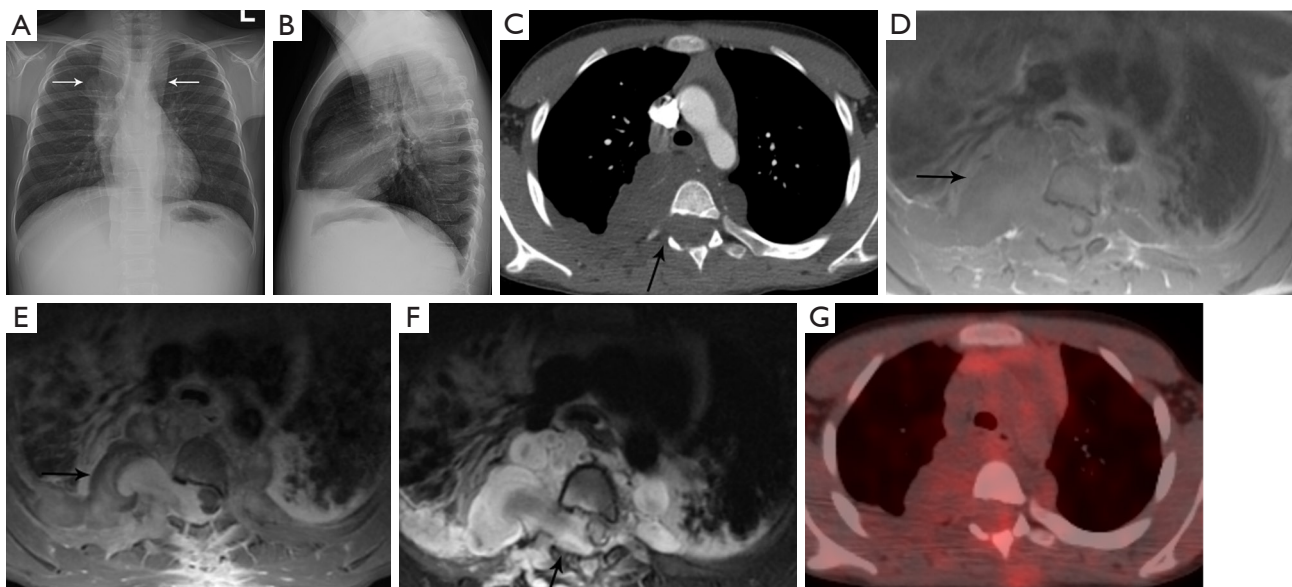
Ganglioneuroma. (A,B) PA and lateral chest radiographs show elongated bilateral posterior mediastinal lesion (arrows) extending from the neck down to below the diaphragm. (C) Axial contrast enhanced CT shows bilateral paraspinal masses with low attenuation and enlargement of the right neural foramen of T4 (arrow) with extension into the spinal canal. (D) Axial T1-weighted MRI shows the mass (arrow) is heterogeneous with iso- to hyperintense signal. Extension into the spinal canal displaces and the spinal cord to the left with abnormal signal intensity within the cord due to cord compression and edema. (E) Axial T1-weighted post-contrast MRI shows the mass (arrow) enhances heterogeneously. (F) Axial T2-weighted MRI shows the mass (arrow) is heterogeneously hyperintense. (G) Fused PET/CT shows the ganglioneuroma is not FDG avid. Biopsy confirmed ganglioneuroma. PA, posterior anterior; CT, computed tomography; MRI, magnetic resonance imaging; PET, positron emission tomography; FDG, fluoro-2-deoxy-D-glucose.
